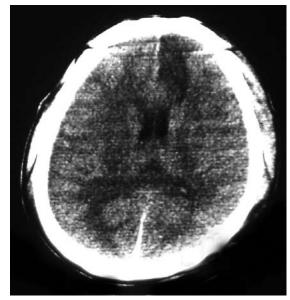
Postoperative follow-up axial CT image shows a small ipsilateral frontal infarction that was responsible for the patient's motor deficits.
